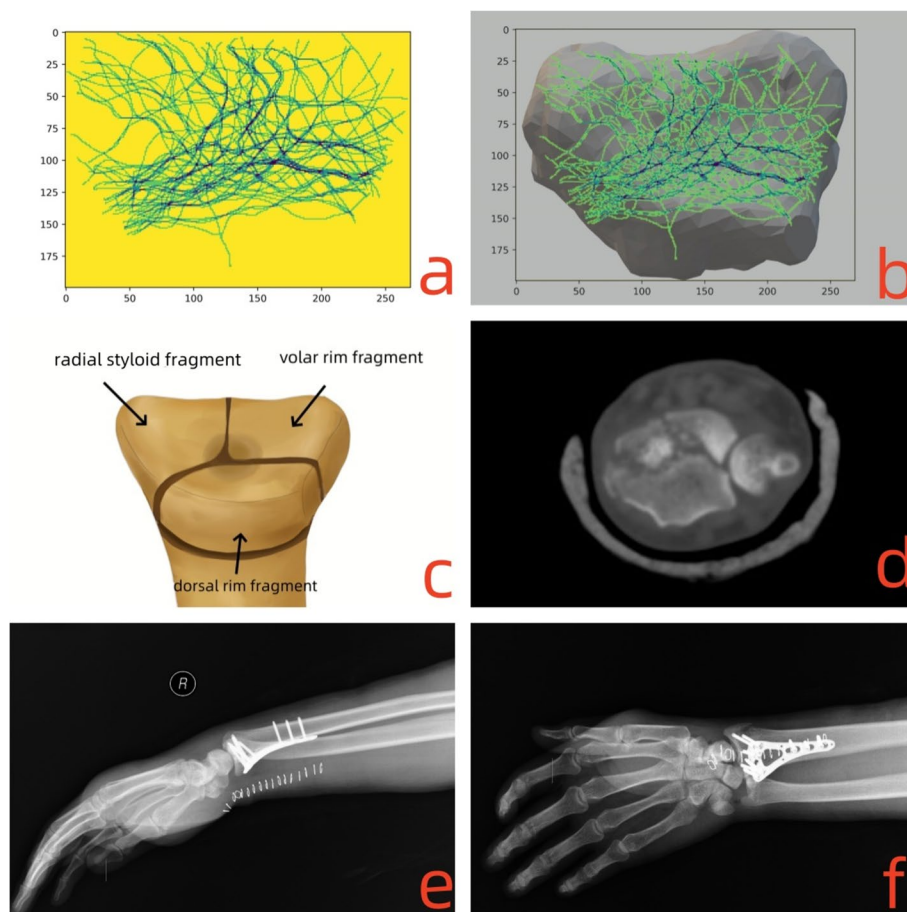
For type 2.2 DRFs, the fracture lines traversed coronally through the articular surface and extended to the volar side like “L” shape. The morphological characteristics and the clinical treatment were shown as follows: a-b) the fracture lines clustered and covered on the intra-articular surface; c) the model for type 2.2 DRFs; d) the CT scan for the fracture lines at the articular surface; e-f) postoperative posteroanterior and lateral X-ray images
